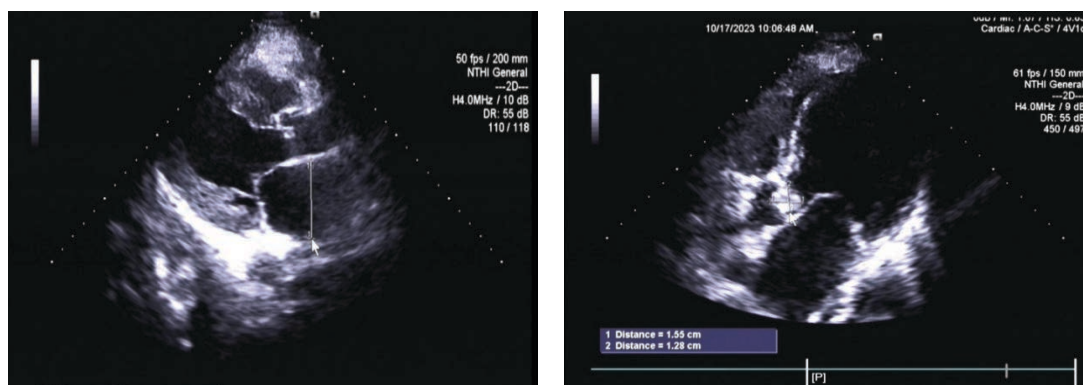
Cardiac color ultrasound.
